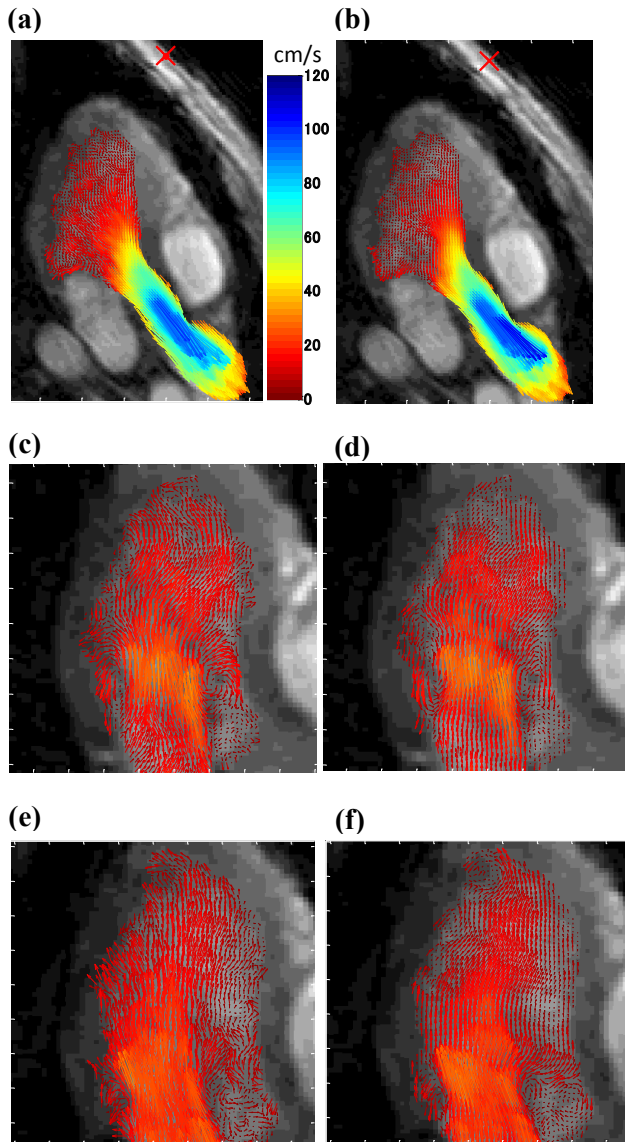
Blood velocity mapping in normal LV comparing the velocity field of the original PC-MRA measurements (PC-MRA) and the velocity field of EDG applied on virtual color Doppler echocardiography (EDG). (a) PC-MRA, (b) EDG at ejection phase, (c) PC-MRA, (d) EDG at early rapid filling, (e) PC-MRA, (f) EDG at atrial contraction. The vectors indicate the direction and magnitude of the velocity as coded in the color bars (cm/s). The cross (x) located at the apex of LV on T2WI represents the virtual probe position.
